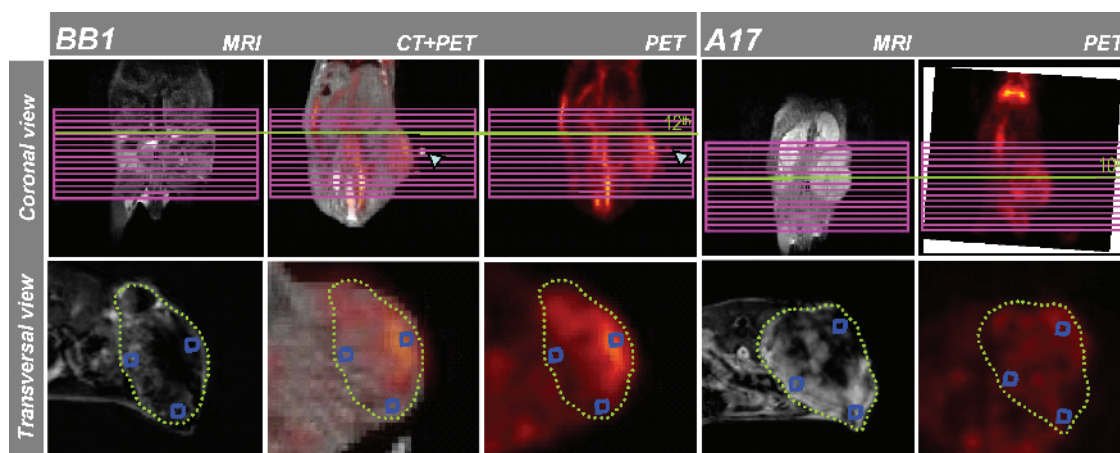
Selection and matching of coarsely corresponding Gd-DTPA-MRI and FDG-PET tumor sections. Each tumor underwent MRI and FDG-PET analysis. For BB1 tumors, CT images were also acquired and coregistered with FDG-PET using at least four spatial markers as reference (cyan arrowheads). One MRI transverse slice per tumor was chosen. The MRI geometric multislice grid was positioned on the coronal view of PET (or CT-PET-registered) acquisitions and used as spatial reference to identify roughly corresponding transverse tumor sections. MRI images were obtained on pixel-by-pixel subtraction of the third postcontrast and the last precontrast dynamic image (see Materials and Methods). For each tumor, two to four ROI (blue frames) were placed on high- and low-enhanced regions of MRI images, and corresponding ROI were identified in CT-PET and/or PET sections. The values of MRI enhancement were normalized with respect to the signal intensity of the reference standard. The values of FDG uptake were normalized with respect to the mean value of the liver.
